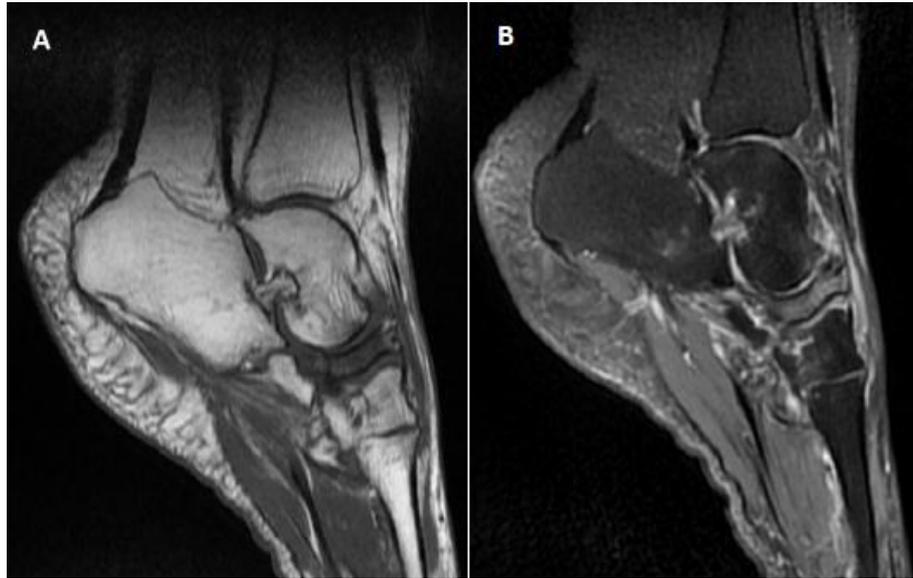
Sagittal MRI of the right foot showing a collapse of the navicular bone with low signal intensity on T1-weighted image (A) and hyper signal on T2-FAT SAT weighted image (B) of the tarsal navicular.
